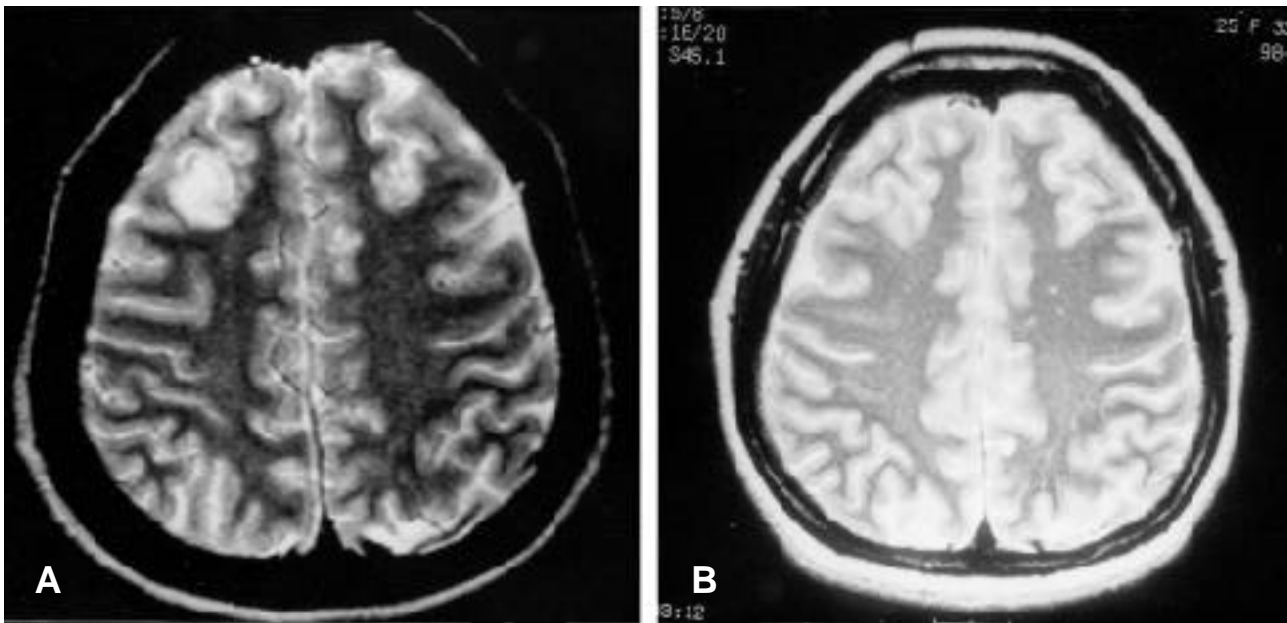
Axial T2 weighted MRI performed 2 days after onset shows bilateral frontal lobe high-signal intensity lesions (A). MRI 4 days later, shows markedly decreased high-signal intensity lesions (B)
